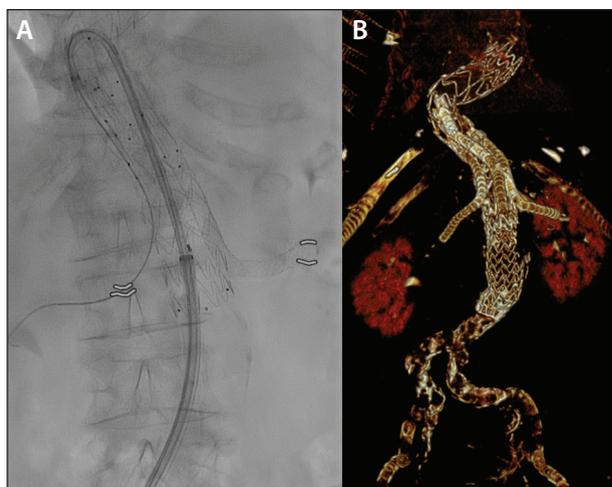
E-nside case. Retrograde cannulation of the right renal branch and artery with a steerable sheath (A). Postoperative 3D CTA after implantation. Note the elongation at the proximal side of the endograft (B).
